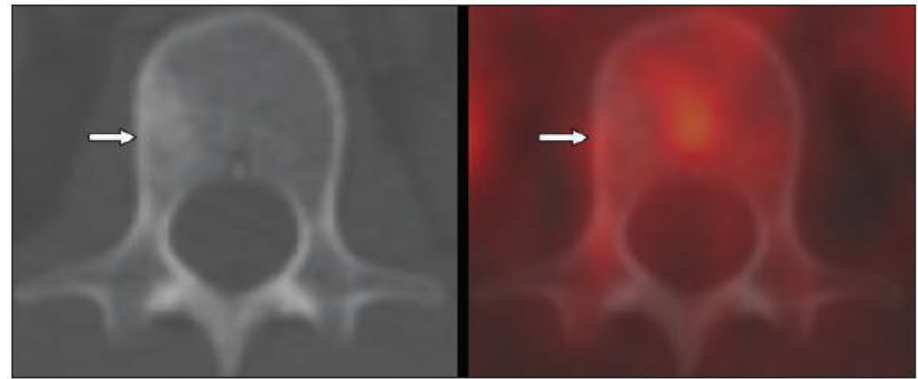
35-year-old woman with Ewing sarcoma (ES). Bone metastases detected on bone scan but not on 18F-FDG PET/CT.
